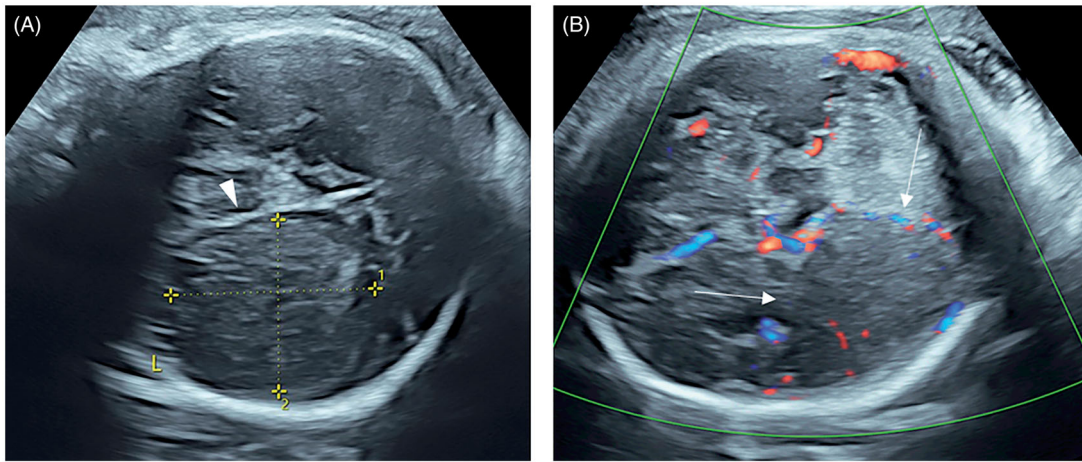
Ultrasonography (US) findings of 37 weeks gestation. (A) A huge solid mass with regular shape and hazy margin is replacing and compressing the cerebral hemispheres. The adjacent midline structure (arrowhead) is slightly deviated to right side. (B) Power Doppler Flow Imaging shows Subtle blood flows in the mass (arrows).
